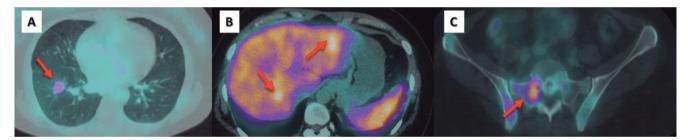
68Ga-PSMA uptake in metastatic lesions, indicated by the red arrow: lung (Fig.1A), liver (Fig.1B) and bone (Fig.1C) metastases.
